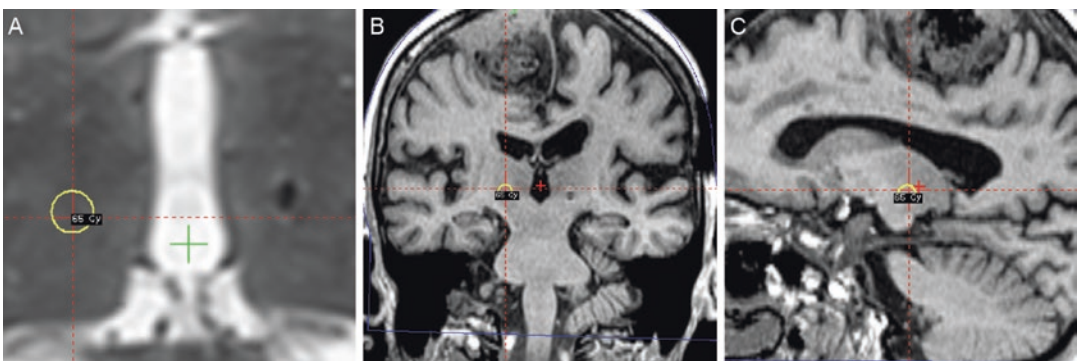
Planning a right-sided GK thalamotomy for a patient with a previously placed left Vim DBS lead, as depicted on (a) axial, (b) coronal, and (c) sagittal MRI sections. The right Vim was treated with a prescription dose of 65.0 Gy to the 50% isodose (yellow circle) with a maximum dose of 130.0 Gy. The coronal and sagittal sections
